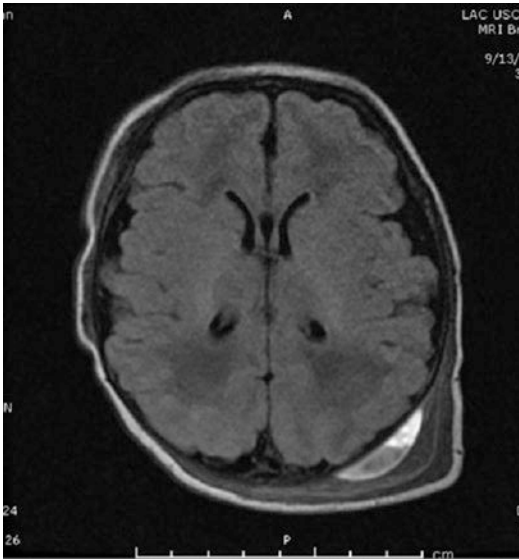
MRI of the brain showing cephalohematoma beneath subgaleal hematoma
